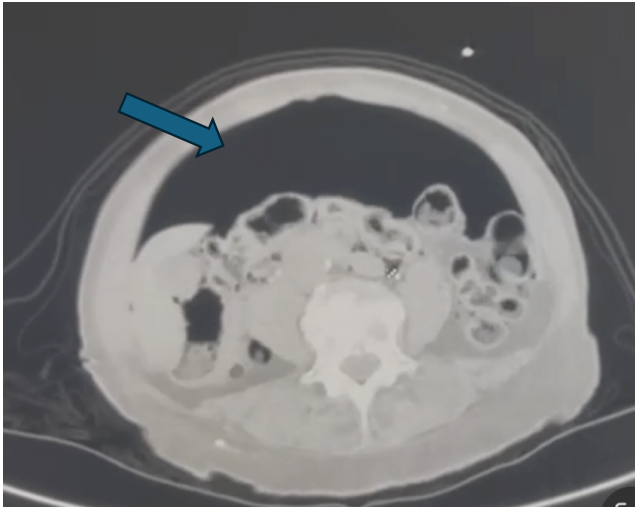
Axial view of CT abdomen with massive pneumoperitoneum (arrow)
